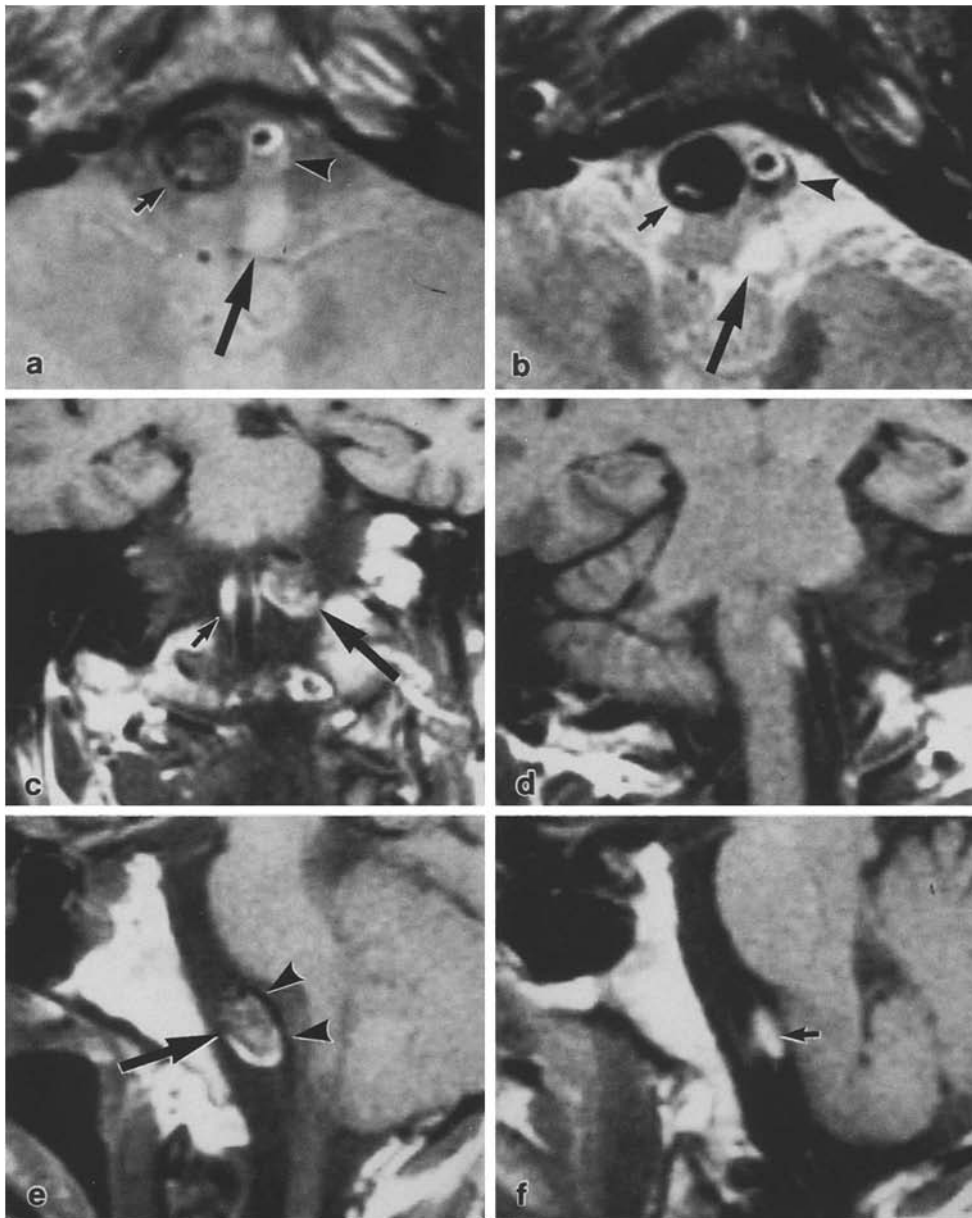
a-f. Case 2. PD-weighted (a) and T2-weighted (b) axial images demonstrating two lesions in the premedullary cistern. The left lesion is seen to consist of a circle and a crescent-shaped part (arrowheads). The circle is relatively thick and demonstrated as an increased intensity on both PD-weighted and T2-weighted images. The crescent-shaped part is demonstrated as being isointense on the PD-weighted image and as being hypointense on the T2-weighted image. The right lesion is larger than the left, and depicted as being hypointense with an inside vague isointensity on the PD-weighted image and an inner hyperintense spot on the T2-weighted image (small arrows). Pontine infarction is seen as a hyperintense area (large arrows). T1-weighted coronal (c) and sagittal (f) images at the plane including the left vertebral artery showing a thickening of the arterial wall as being hyperintense (small arrows). T1-weighted coronal (c, d) and sagittal (e) images at the plane including the right vertebral artery depicting an oval mixed-intense mass (large arrows) located ventral to the arterial lumen (arrowheads)
